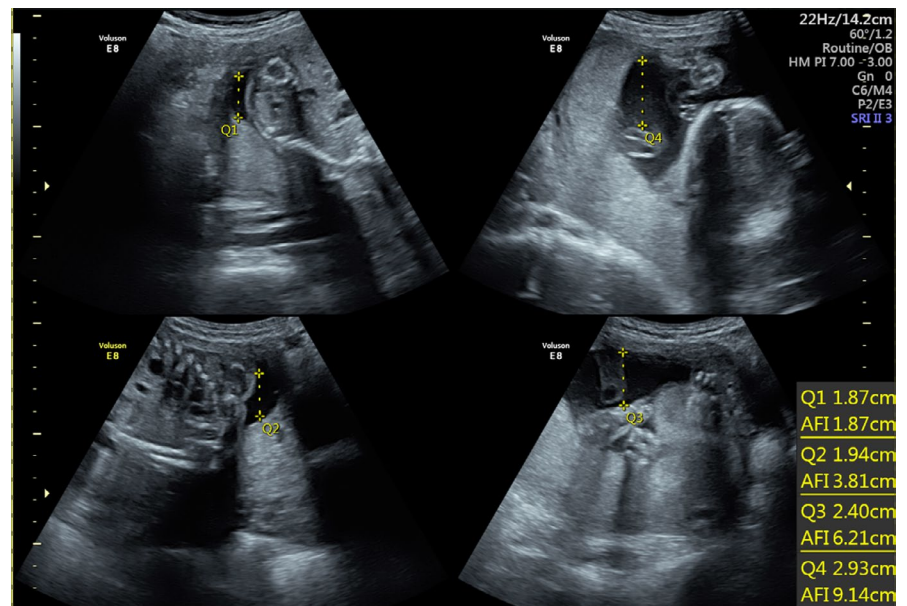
Ultrasonographic assessment of the amniotic fluid index at 20 wk and 5 d of gestation
